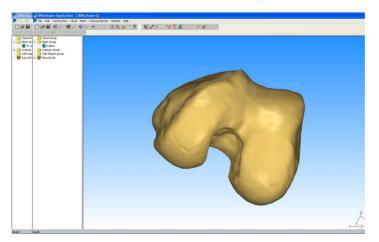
Model of the knee-joint obtained on the basis of studies on CT from the 3D Reshaper program.
